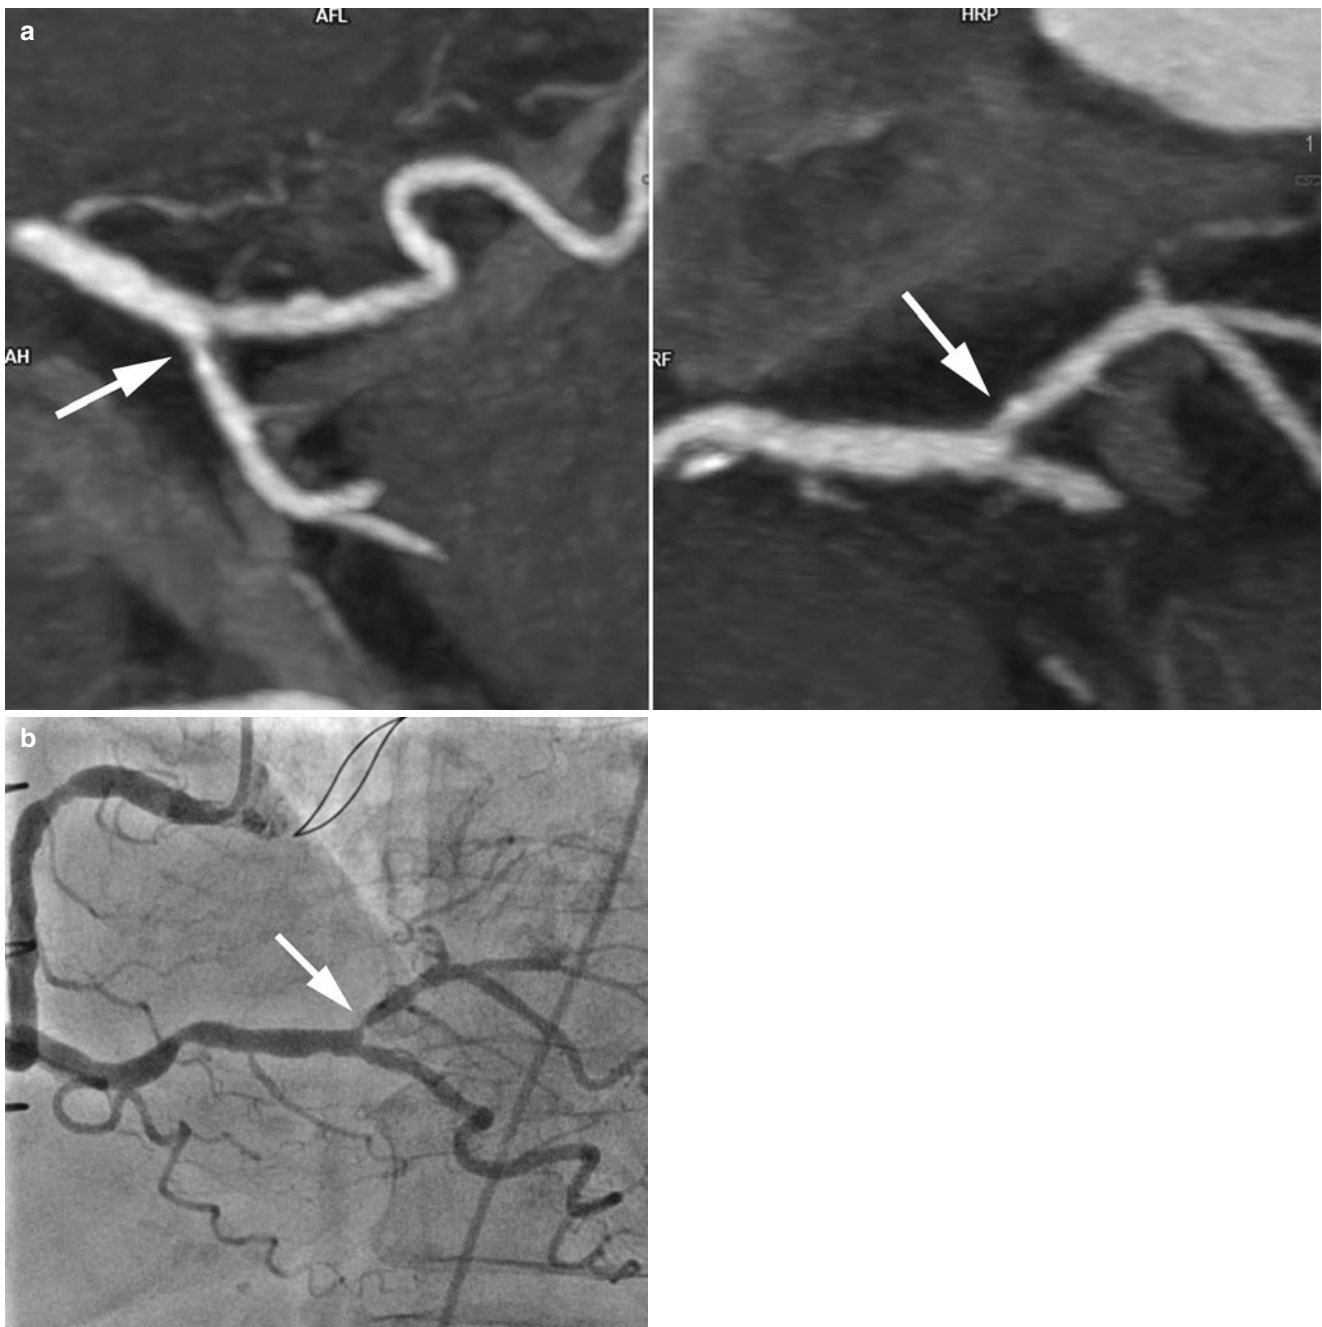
False-positive finding in coronary CT angiography, small vessel. (a) Coronary CT angiography (maximum intensity projection) of the posterior descending coronary artery, a branch of the right coronary artery. A severe luminal stenosis seems to be present (arrow). (b)
